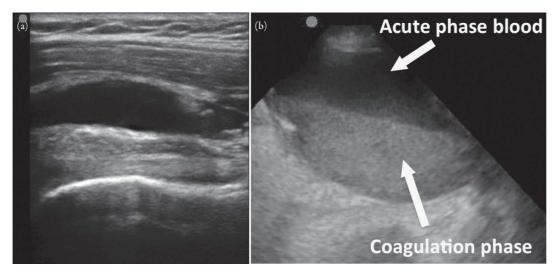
(a) Hematoma over the humeral head on ultrasound. (b) Both acute and coagulated blood seen within hematoma.
